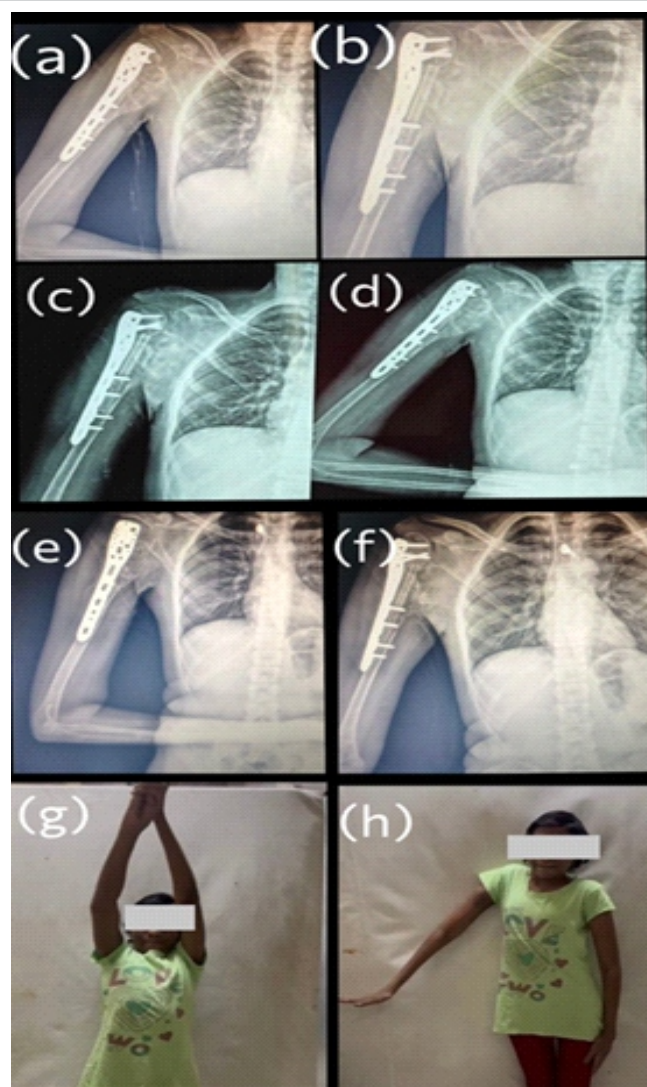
Follow-up radiographs at 1, 3 and 6 months showing maintained fixation of the proximal humerus with PHILOS plate and fibular strut graft, with no evidence of recurrence of Aneurysmal Bone Cyst. (a),(c),(e) Anteroposterior view (b),(d),(f) Lateral view (c, d) Clinical photographs demonstrating satisfactory functional range of motion of the right shoulder at 6 months postoperatively
